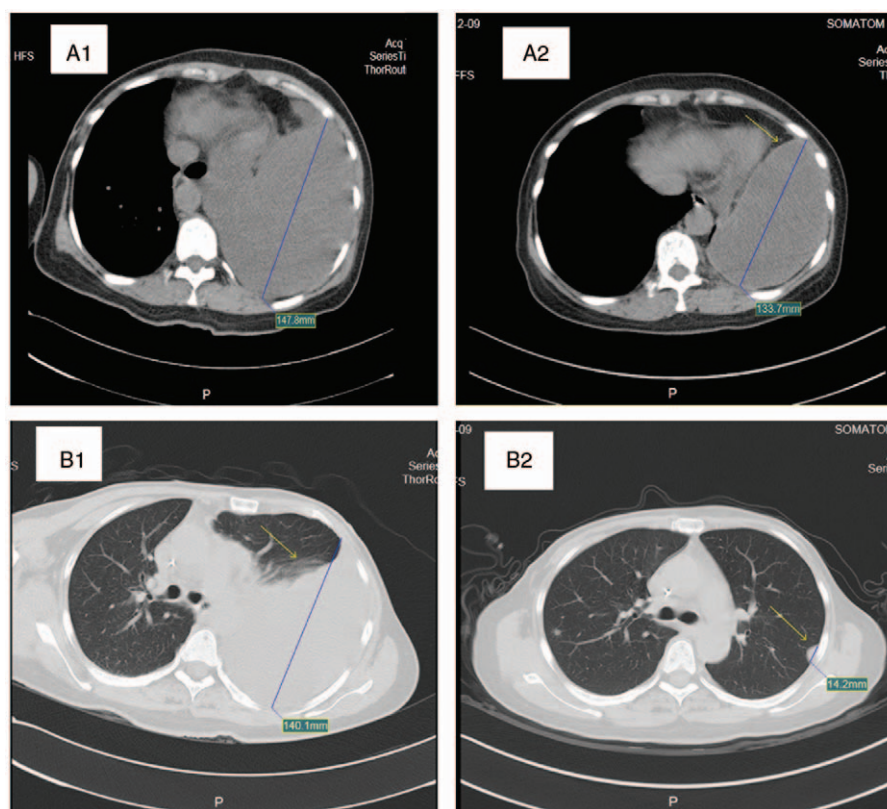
Computerized tomography (CT) scans. Initial CT scan of mediastinal window (A1) and pulmonary tissue (B1) with a massive pleural effusion and in the pleural cavity; later CT scan of mediastinal window (A2) and pulmonary tissue (B2) showing significant changes in tumor size and pleural effusion after 6 cycles of chemotherapy and 3 treatments with recombinant human interleukin 2 injection into the pleural cavity (yellow arrow).
